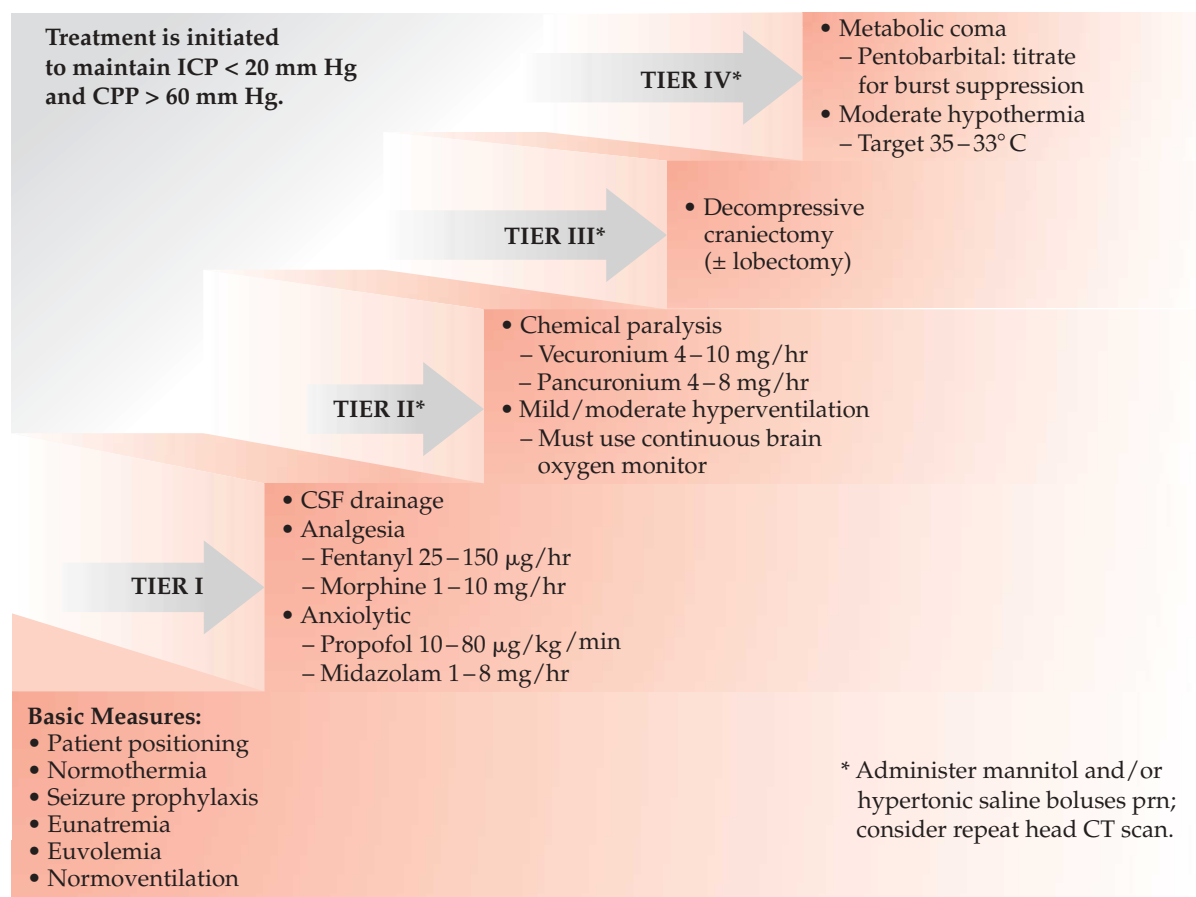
ICP = intracranial pressure; CPP = cerebral perfusion pressure; CSF = cerebrospinal fluid; CT = computed tomography.
